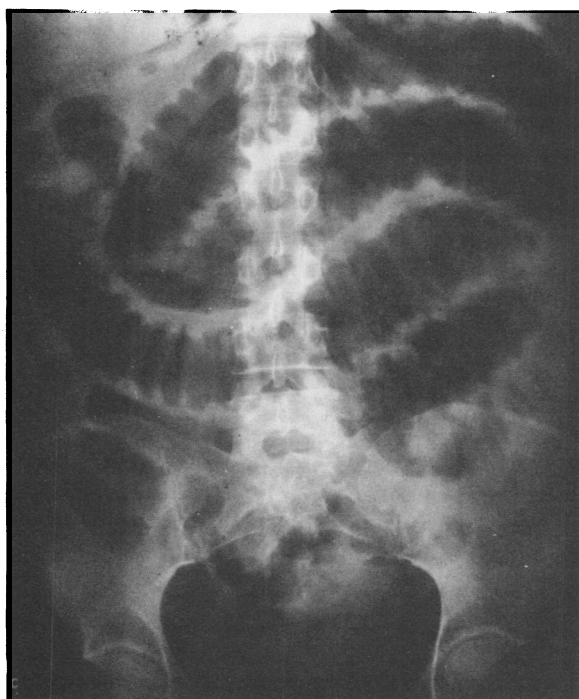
Roentgenogram of the abdomen showing dilated loops of small bowel and the thickened, edematous intestinal wall.
